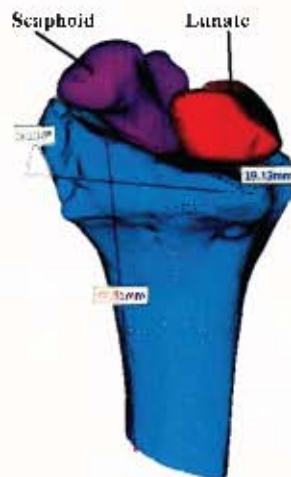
The distal portion of the radius, scaphoid and lunate derived from a volunteer's CT-scan (Appendix D).
